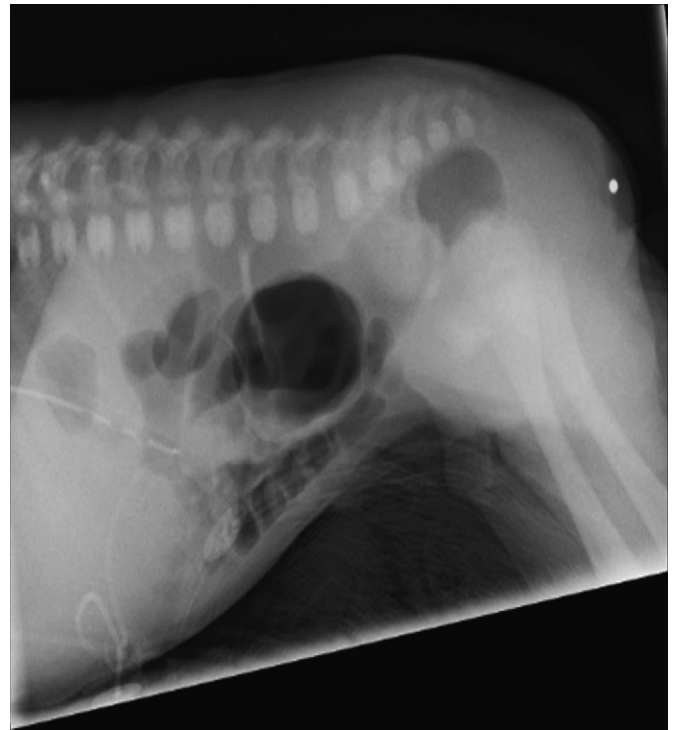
Cross-table lateral radiograph, high rectum.
